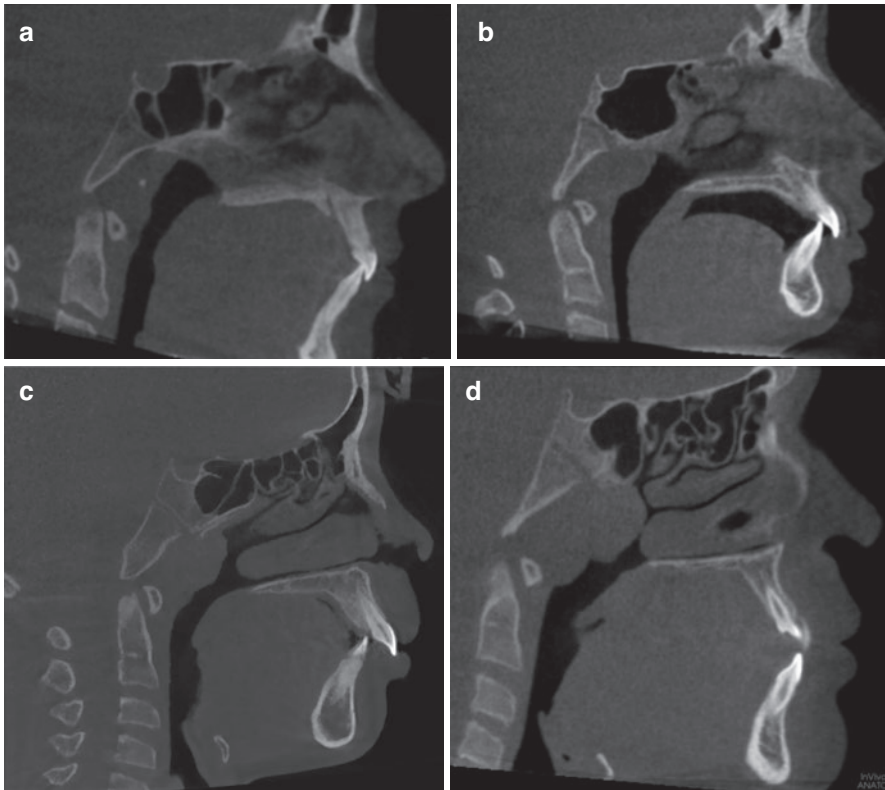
Sagittal CBCTs in different patients show the different degrees of adenoid enlargement: (a) Grade 1, less than 25% obstruction of the nasopharynx; (b) Grade 2, 25–50% obstruction; (c) Grade 3, 50–75% obstruction; and (d) Grade 4, >75% obstruction
